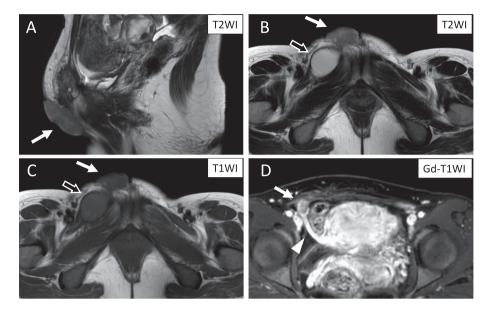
Contrast-enhanced pelvic magnetic resonance imaging. A 6-cm solid mass (A, B, C, D: white arrow) is seen in the right inguinal region. A cystic component is located at the lateral caudal site of the solid mass (B, C: black arrow), with a thin, regular, smoothly demarcated wall. The solid mass is thought to have continuity with the round ligament (D: arrowhead) in the right inguinal canal. (A: sagittal section, T2-weighted image; B: transverse section, T2-weighted image; C: transverse section, T1-weighted image; D: transverse section, contrast-enhanced T1-weighted image).
